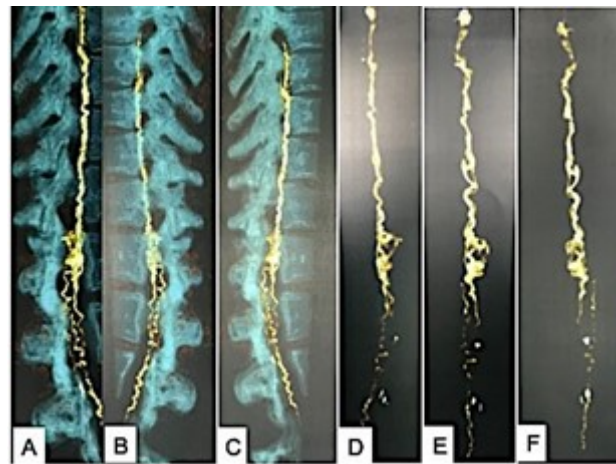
(A–F) CTA of dorsolumbar spine showing lower dorsal spinal SVM. Source: Figure by authors.
